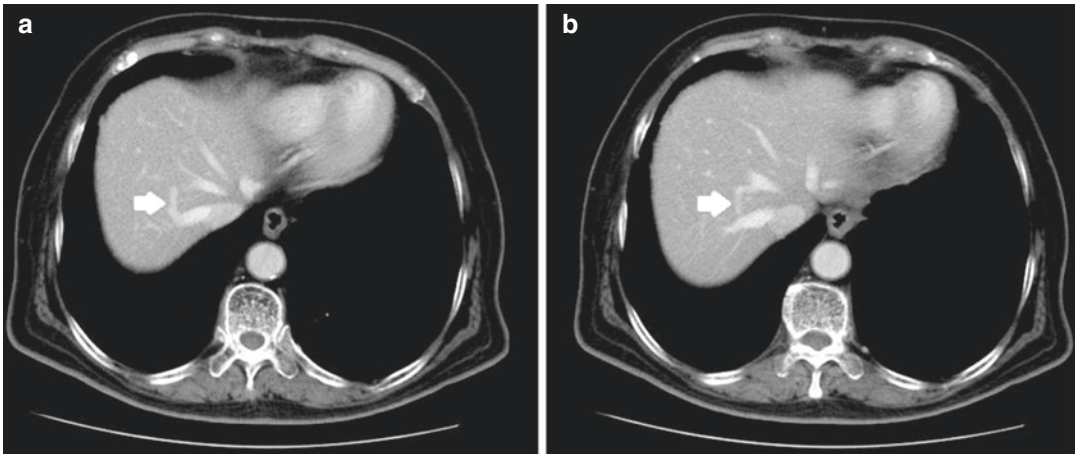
Preoperative contrast-enhanced computed tomography images (a, b, continuous) demonstrating the anastomosis between the right and middle hepatic vein (arrows)
